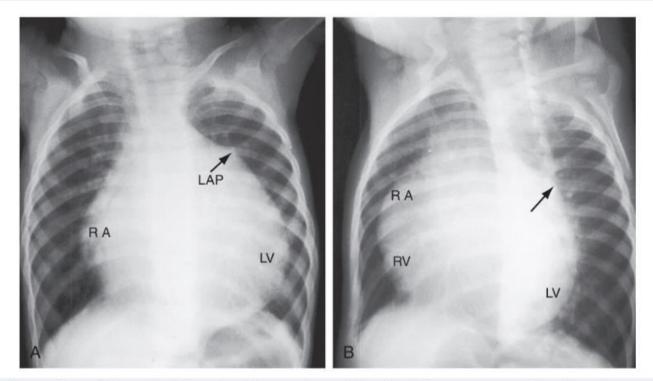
X-rays from a 10-month-old female with anomalous origin of the left coronary artery from the pulmonary trunk. A, The left atrial appendage (LAP) is conspicuous, a dilated left ventricle (LV) occupies the apex, and an enlarged right atrium (RA) occupies the right cardiac border. B, Left anterior oblique projection. The anterior border of the heart is formed by the right atrium and right ventricle (RV), the posterior border is formed by the dilated left ventricle, and a large left atrium lies beneath the left bronchus (arrow).
